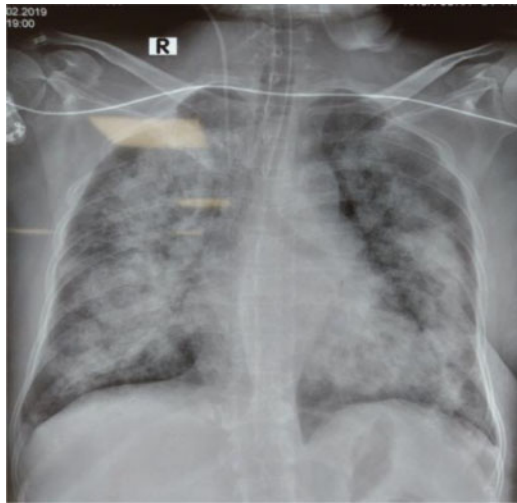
Chest radiograph revealing bilateral ground-glass opacity reflecting fluid filling of the alveolar spaces.
